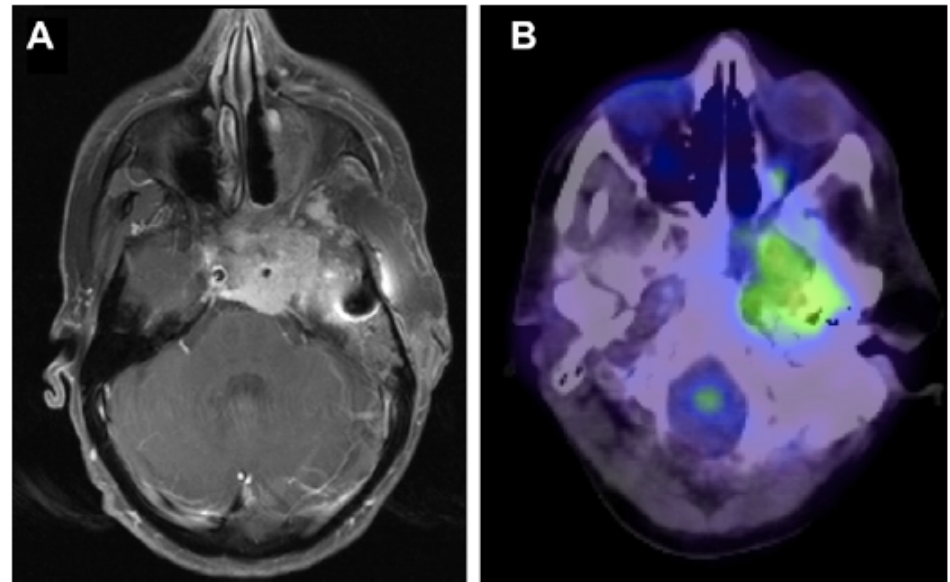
Planning scans; (A) contrast-enhanced MRI and (B) PET-CT.
